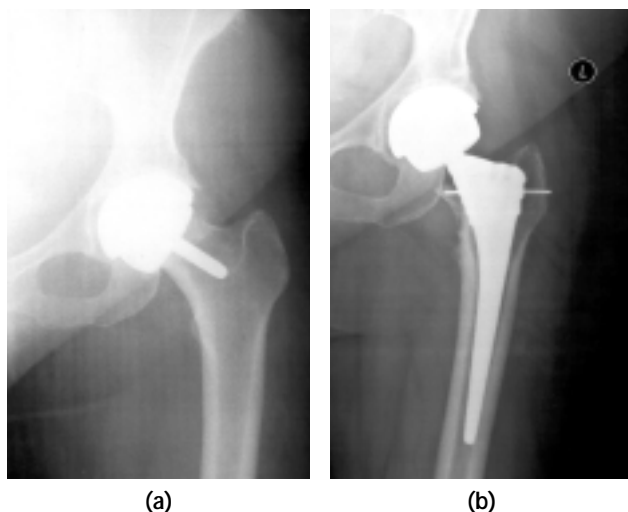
Case 1: (a) preoperative radiograph showing femoral neck fracture of the left hip with metal-on-metal hip resurfacing prosthesis *in situ*; (b) postoperative radiograph showing revision of the femoral component.
